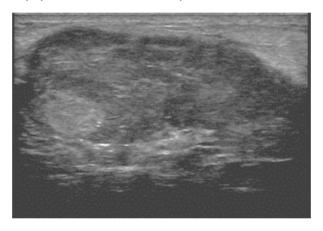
Ultrasound image shows a large solid, heterogeneous mass, with hyperechoic, cystic areas intermixed and lobular margin. (Bentzer et al.2016)
